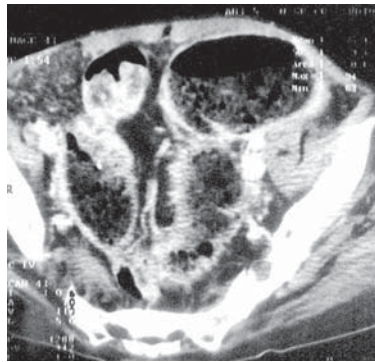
CT scan showing rectosigmoid carcinoma with local extramural invasion and proximal intestinal obstruction
